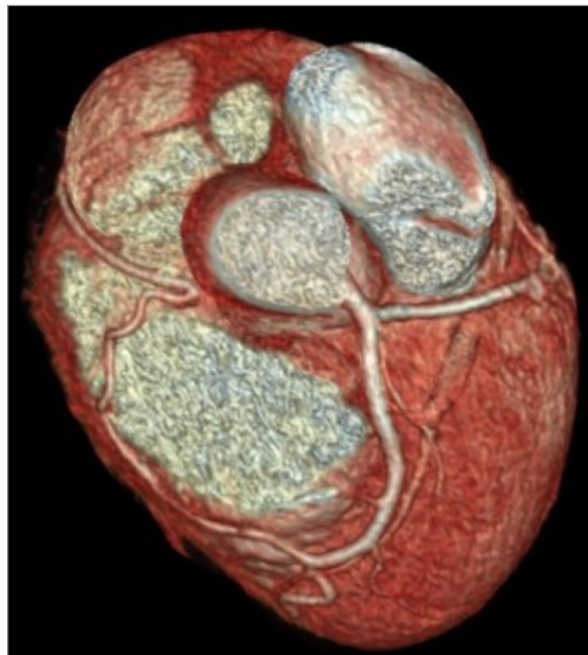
Computed tomography coronary angiogram 3-dimensional reconstruction, showing anomalous origin of the right coronary artery from the left anterior descending artery at the midlevel, with a prepulmonic course.
